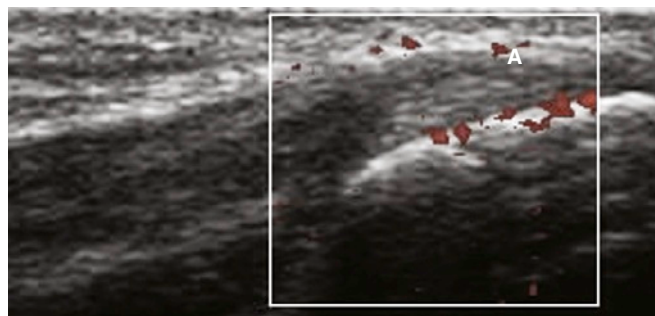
In cortical enthesitis, a flash artifact of Doppler can be seen at the insertion of the lateral epicondyle in this longitudinal scan.
